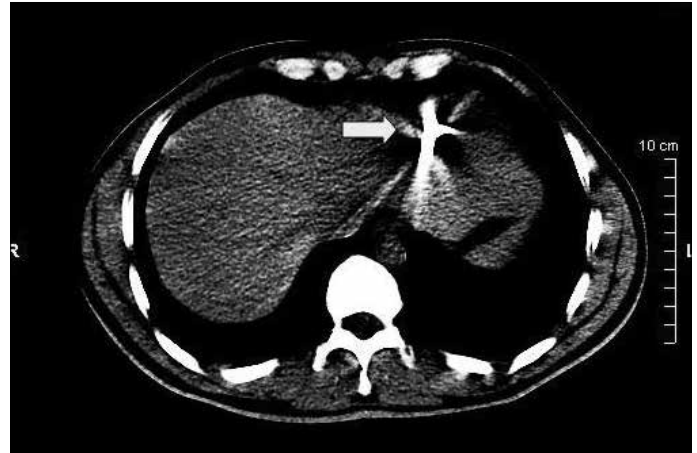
Thorax computed tomography image of foreign body (arrow)
